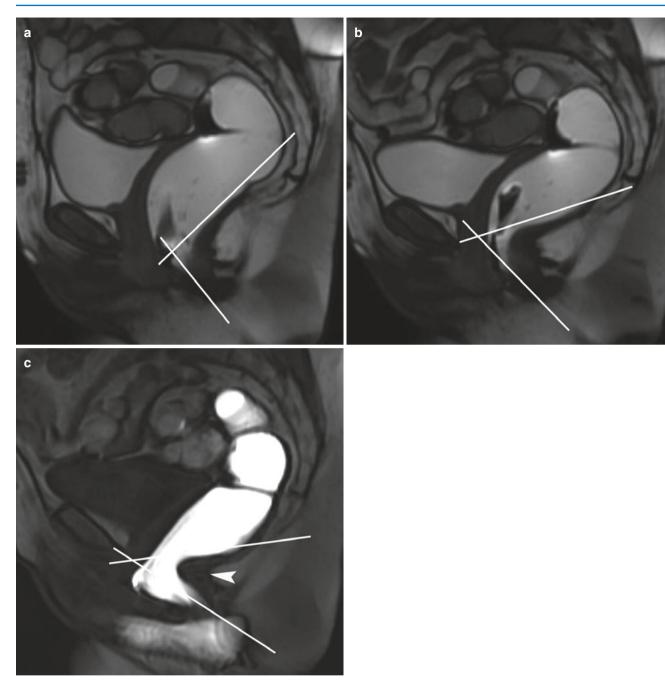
60-year old female patient (s.p. hysterectomy and surgical repair of an enterocele) with clinical suspicion of dyssynergic defecation. On MR images obtained at rest (a) the anorectal angle measures 103° , whereas the anorectal angle during squeezing is 81° (b). During
